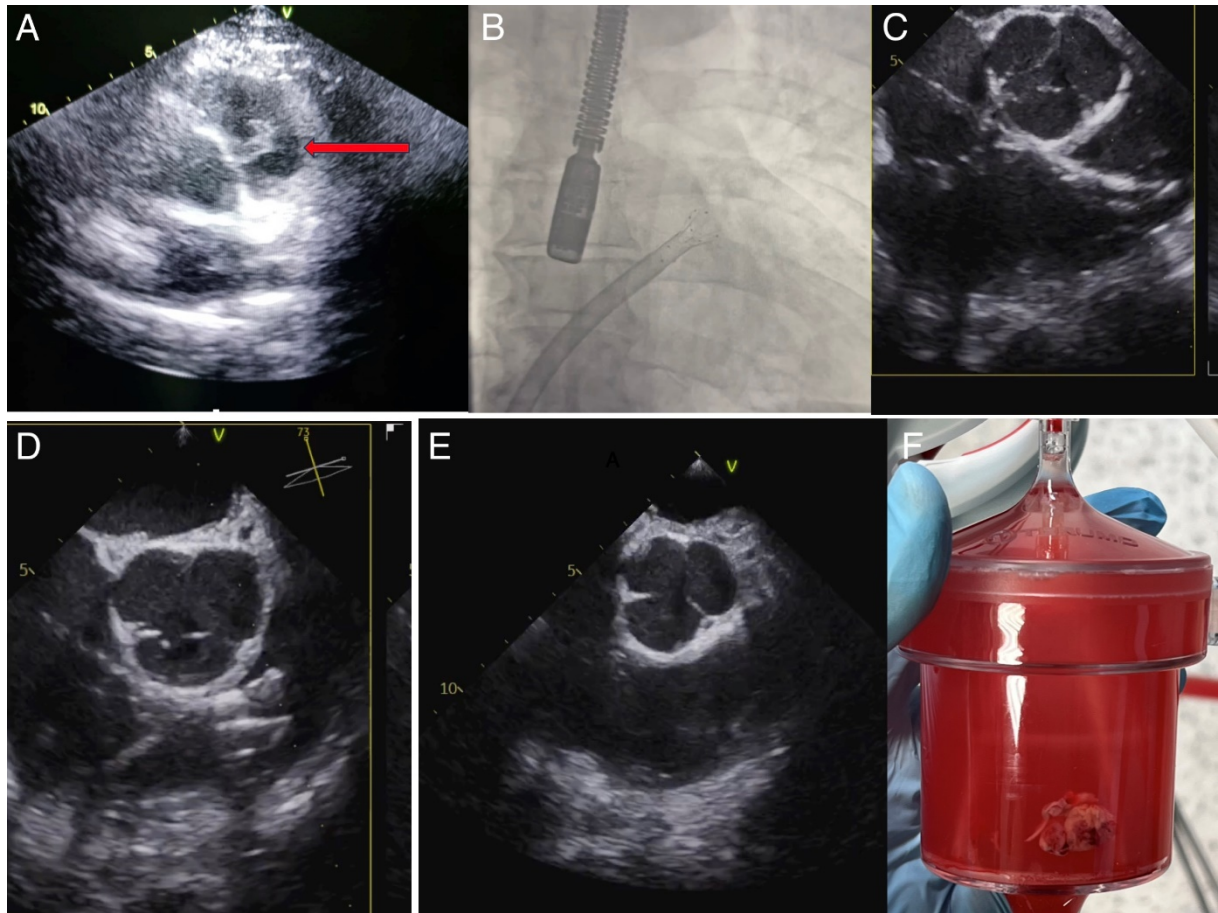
A. The pulmonary valve vegetation (arrow) visualized in transthoracic echocardiogram. B. Fluoroscopy image anterior-posterior view, AngioVac system introduced into the right ventricle under pulmonary valve. C. Angiovac 0–20 degree system not able to reach vegetation because of aorta hugging transoesophageal echocardiogram (TEE) image. D. Angiovac 0–180 degree system able to reach vegetation bin safe distance to pulmonary valve TEE image. E. Post procedure TEE of right ventricular outflow tract. F. Vegetation in filter chamber
